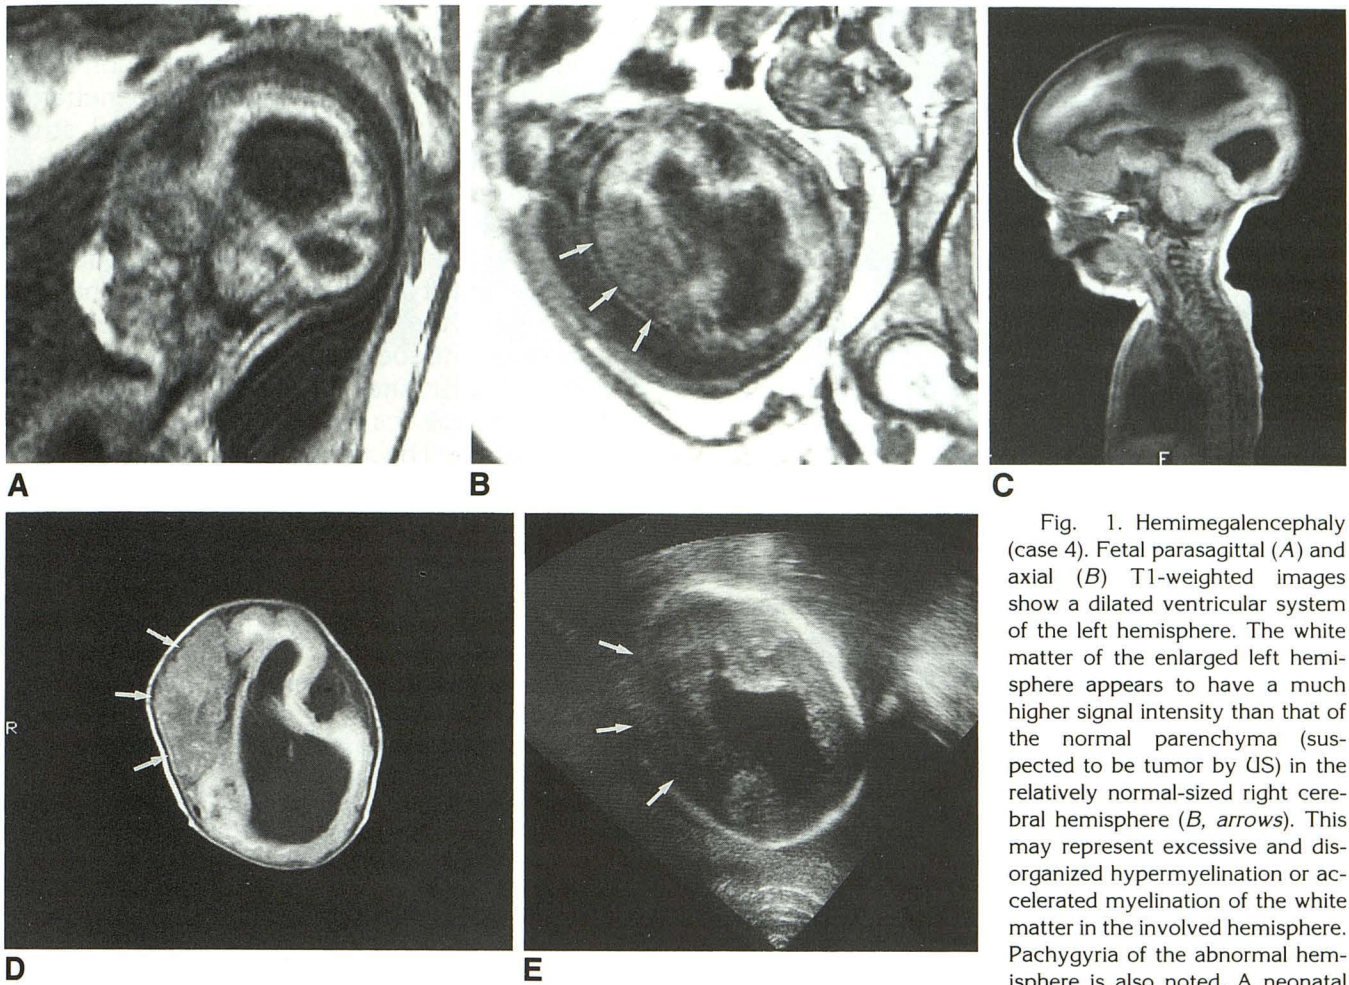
Hemimegalencephaly (case 4). Fetal parasagittal (A) and axial (B) T1-weighted images show a dilated ventricular system of the left hemisphere. The white matter of the enlarged left hemisphere appears to have a much higher signal intensity than that of the normal parenchyma (suspected to be tumor by US) in the relatively normal-sized right cerebral hemisphere (B, arrows). This may represent excessive and disorganized hypermyelination or accelerated myelination of the white matter in the involved hemisphere. Pachygyria of the abnormal hemisphere is also noted. A neonatal parasagittal T1-weighted image
